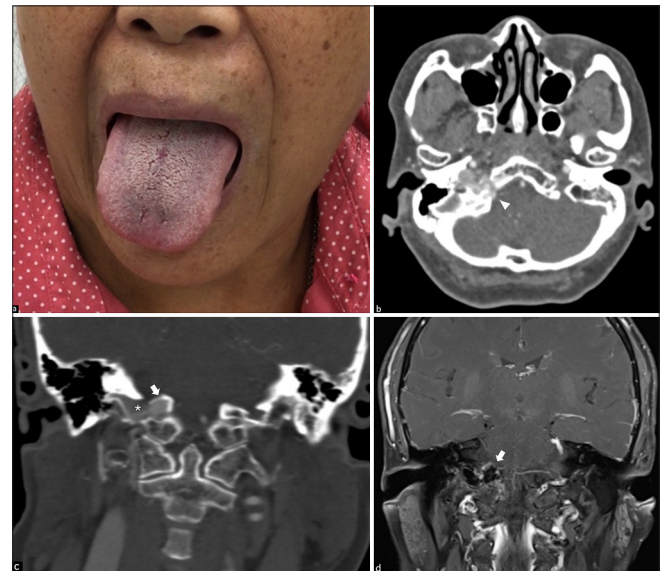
(a) Clinical photograph showing rightward deviation of the tongue. (b) Axial computed tomography angiography (CTA) reveals a dilated venous channel within the right hypoglossal canal (arrowhead). Coronal (c) CTA and (d) contrast-enhanced MRI demonstrating an enlarged right anterior condylar confluence (arrows) with a connection to the jugular bulb through a bridging vein (asterisk).
